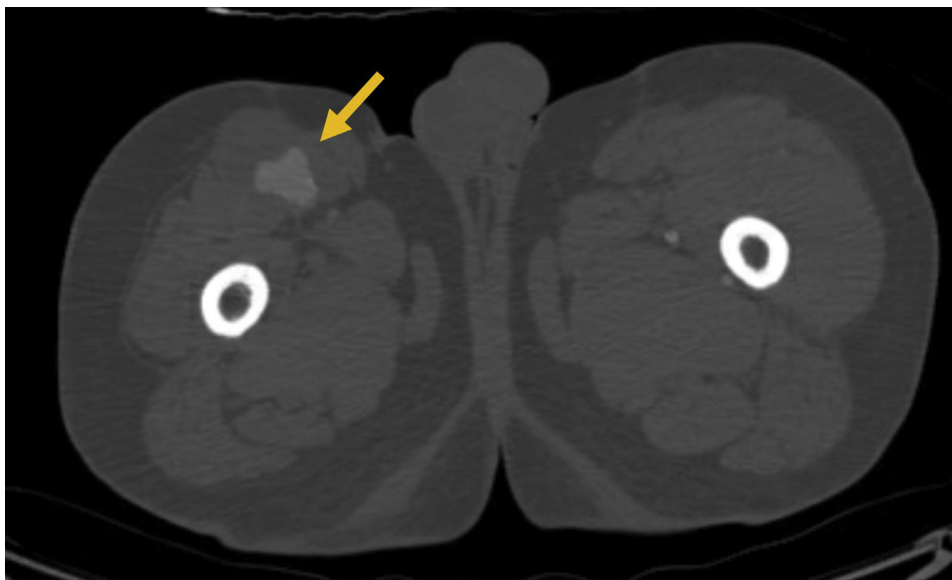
Axial cut of the computed tomography angiogram showing aneurysmal dilatation of the distal right axillofemoral prosthetic polytetrafluoroethylene (PTFE) bypass graft measuring 5.0 × 3.9 cm with extensive mural thrombus (*yellow arrow*).
